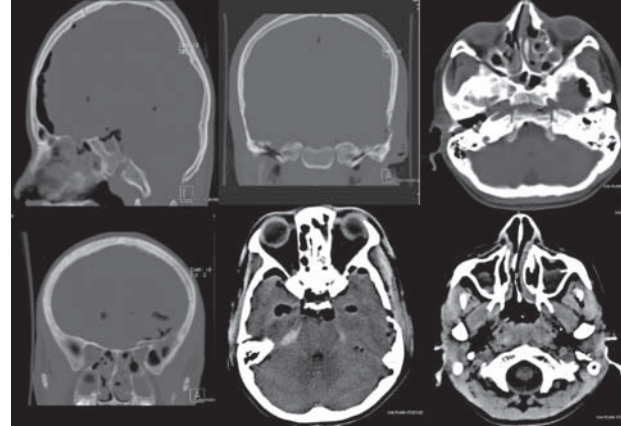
A spiral CT scan 24 hrs following trauma shows a transverse clivus fracture and extension into both petrous temporal bone. A linear fracture involving lesser wing of sphenoid was also seen. Parenchymal windows reveal air in para- and retropharyngeal space. Pneumocephalus shows resolution.
